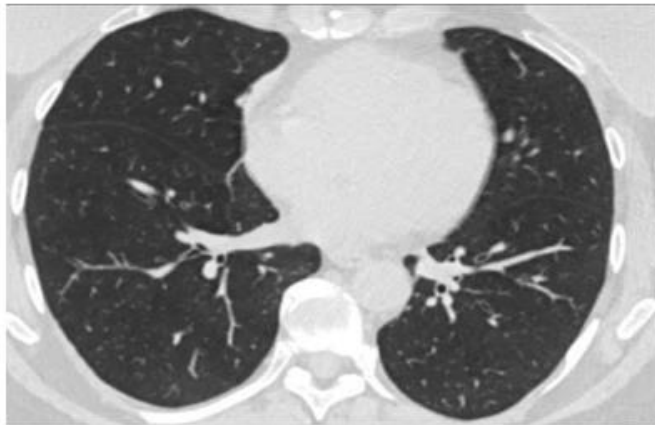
HRCT chest (COVID-19 Reporting and data system-3)
